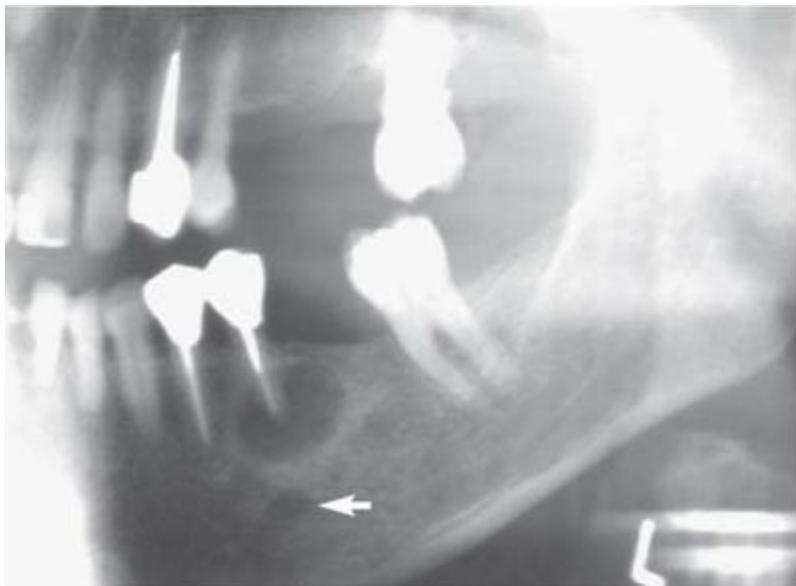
Preoperative evaluation of a mandibular left second premolar included a panoramic radiograph to help locate the mental
